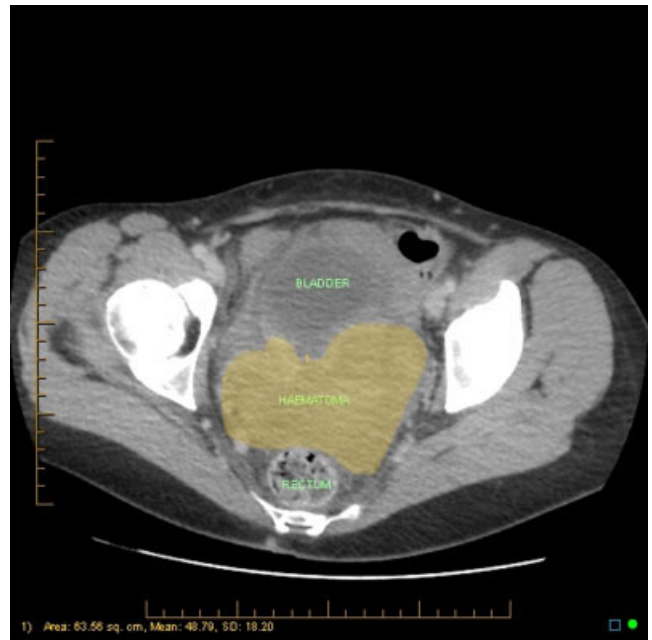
Pelvic pain, dropping hemoglobin consistent with hemorrhage in first 24 hr after a vaginal hysterectomy and CT evidence of a vaginal vault hematoma. Managed conservatively for 4 days, evidence of sepsis (fever, increasing white cell count) prompted vaginal drainage and intravenous antibiotics. Classification: 7B T2 S3 (initially 7A T1 S3).
